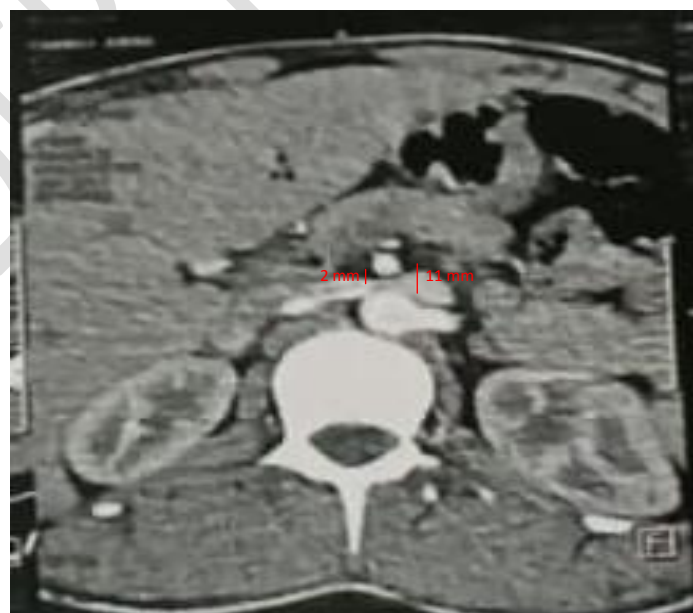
Axial section of the abdominopelvic CT: dilatation of the hilar segment of the left renal vein with a hilar and aortomesenteric portion diameter ratio >5.5 (11:2)
